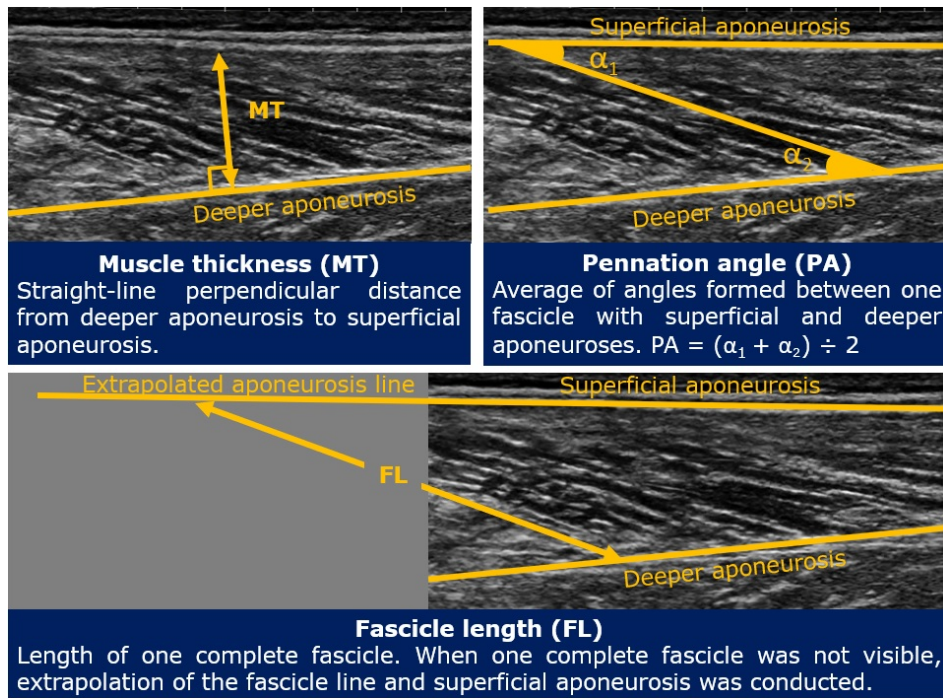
Muscle architecture variables measured on ultrasound images.
